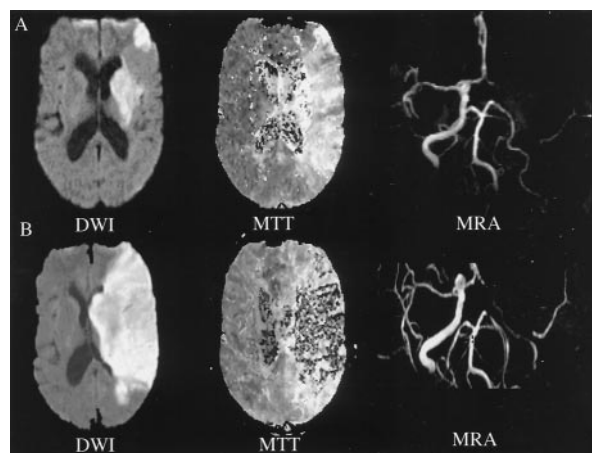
Case example of 50-year-old woman with acute onset of left hemispheric syndrome (NIHSS score 16). A, MRI shows a small hyperintensity in the left basal ganglia on DWI and a large area of prolonged mean transit time (MTT) on PWI in the left MCA territory. MRA shows ICA-plus-MCA occlusion. She was treated with 0.9 mg/kg IV tPA 2 hours and 30 minutes after symptom onset. B, On MRI obtained 24 hours after symptom onset, DWI shows growth of the initial lesion in the territory of distribution of the left MCA. MRA shows no reperfusion of either ICA or MCA on MRA. Her NIHSS score was 11 at 3 days and 14 at 1 month.
